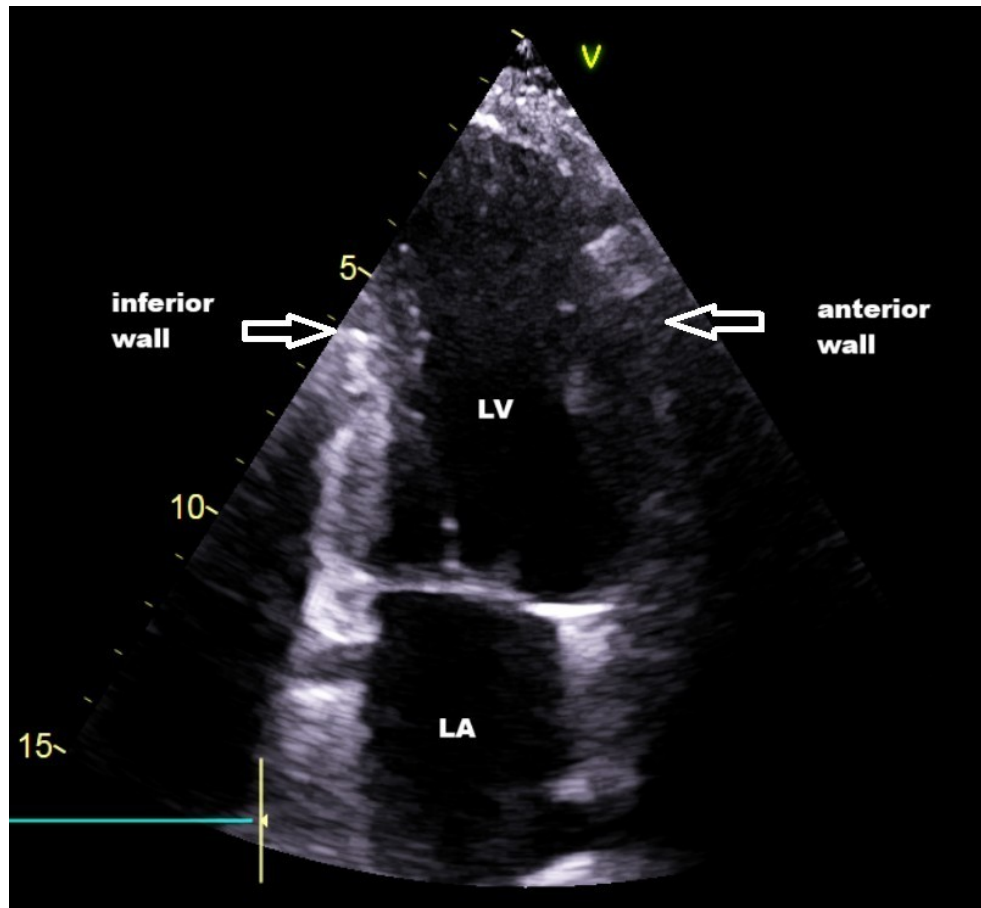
Apical Two Chamber View, LA=Left atrium, LV=Left ventricle
